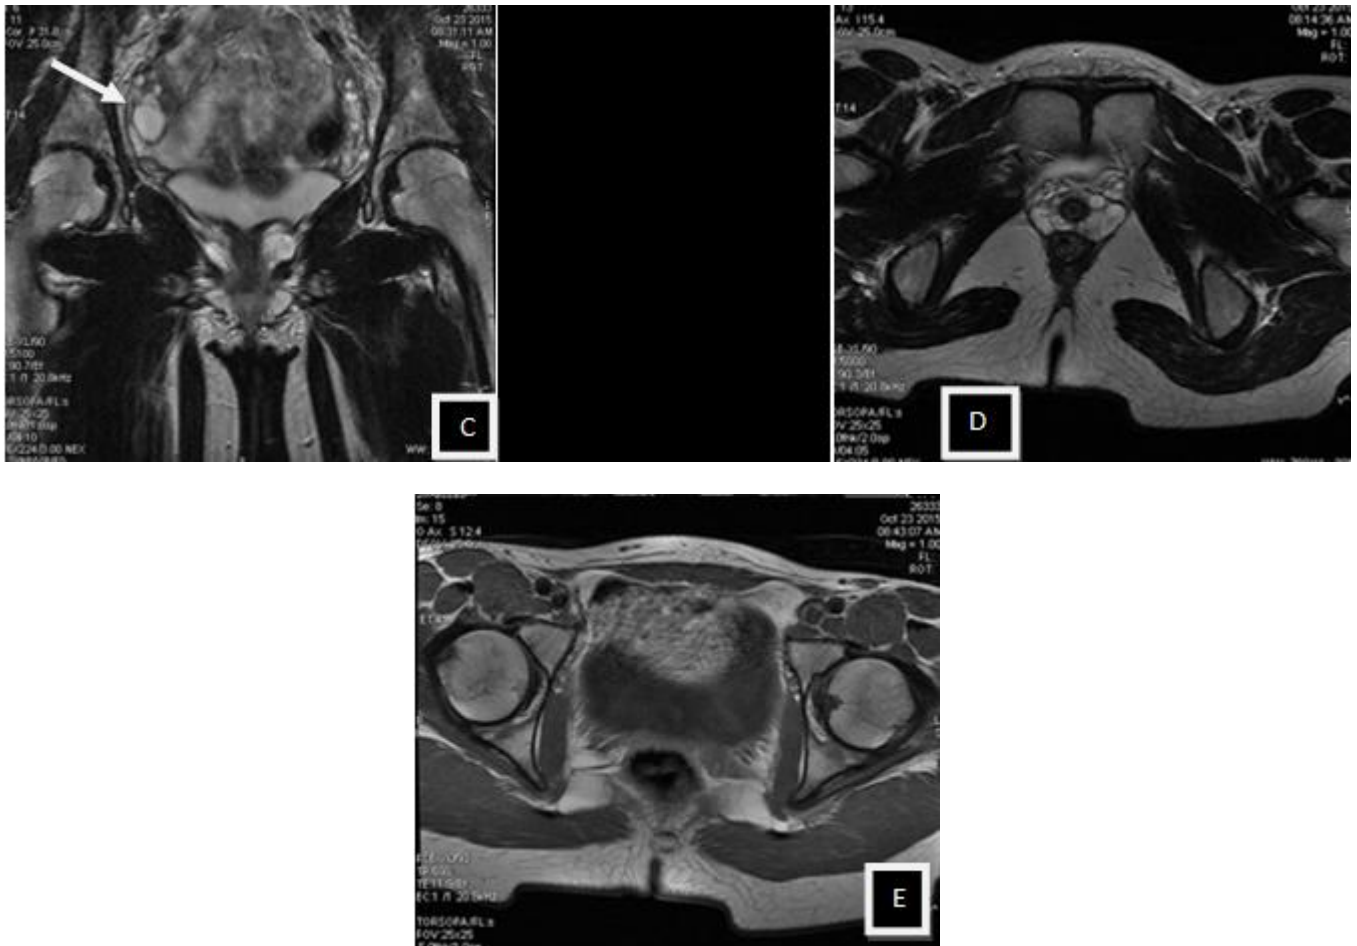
A: Sagittal, MRI T2-weighted image without fat suppression: the uterus is not seen in the uterovesical excavation. B, C: Axial and Coronal T2-weighted image without fat suppression: functional ovaries with normal volume and shape, in their original location→, the right ovary presenting follicular cyst (arrow) and rudimentary ovarian tubes. D: Axial, T2-weighted image: note the absence of the vagina. E: Axial, T1-weighted image: note the absence of the uterus.
